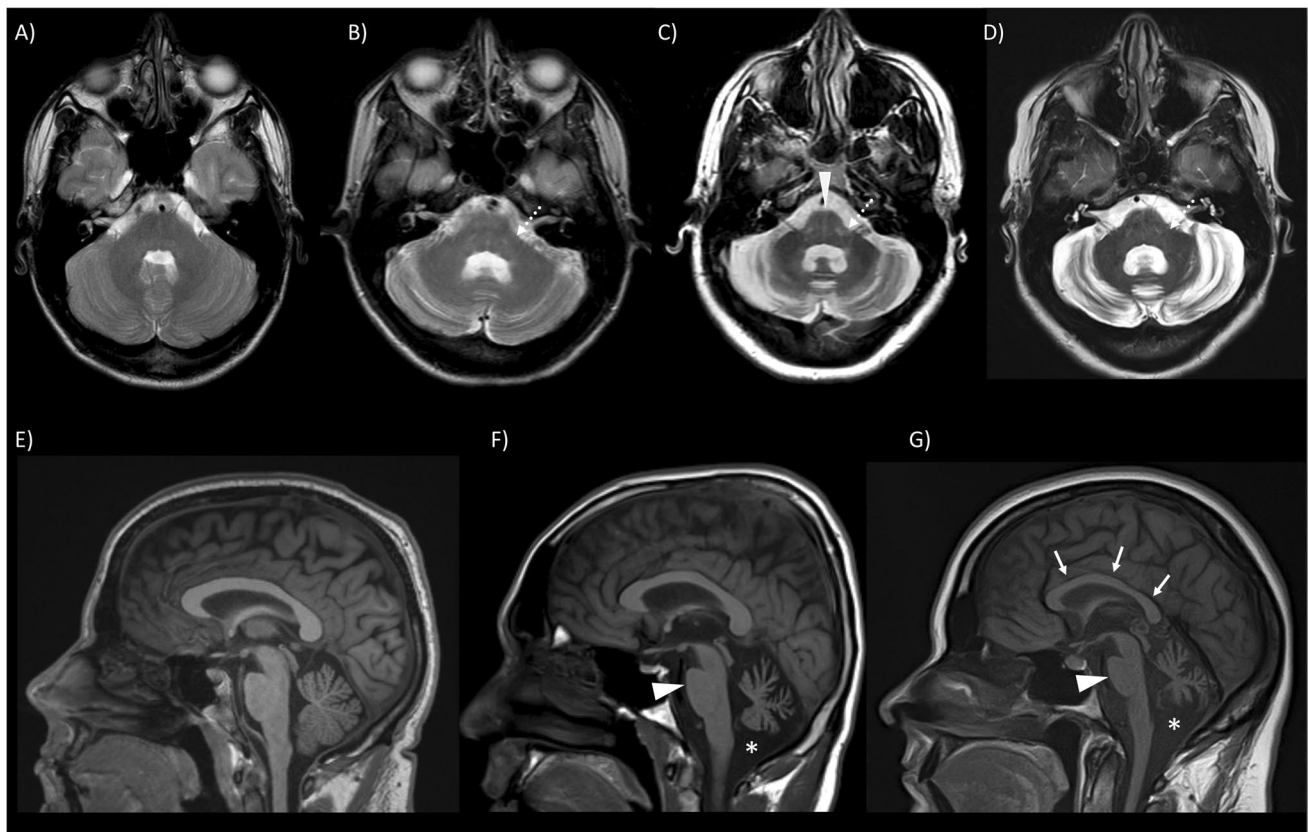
Brain MRI findings in late-onset Tay-Sachs disease. Representative axial T2-weighted images at the level of the 4th ventricle in A) control subject, and LOTS patients with B) mild, C) moderate, D) severe cerebellar cortical atrophy. Note that the 4th ventricle is enlarged and the middle cerebellar peduncle is atrophic (dotted white arrows) in all LOTS patients regardless of the degree of cerebellar cortical atrophy. Vertical line in the pons (white arrowhead)
